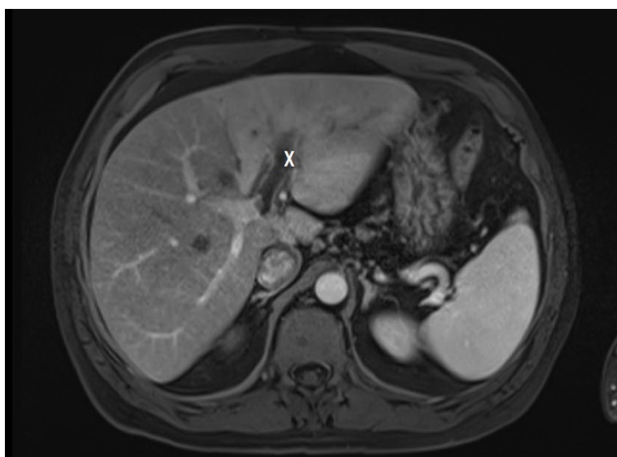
Abdominal MRI (Axial viba arterial view): X Portal vein thrombosis.
